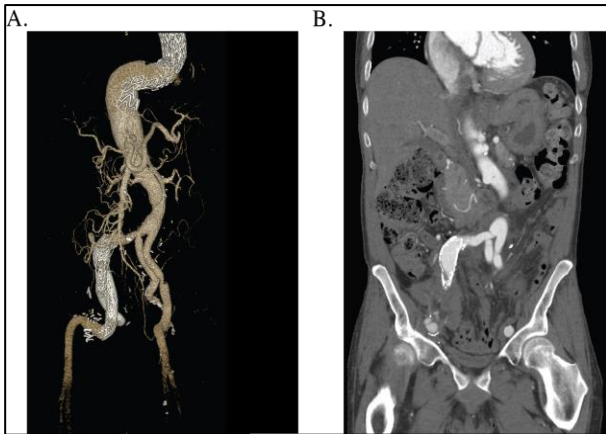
(A and B): Post-operative CTA findings 2 months after open AAA repair. CTA reconstruction demonstrates resolution of the L CIA aneurysm and the bypass from the R limb of the aorto-biiliac graft to the L IIA. Coronal slice on CTA shows the bypass graft.
